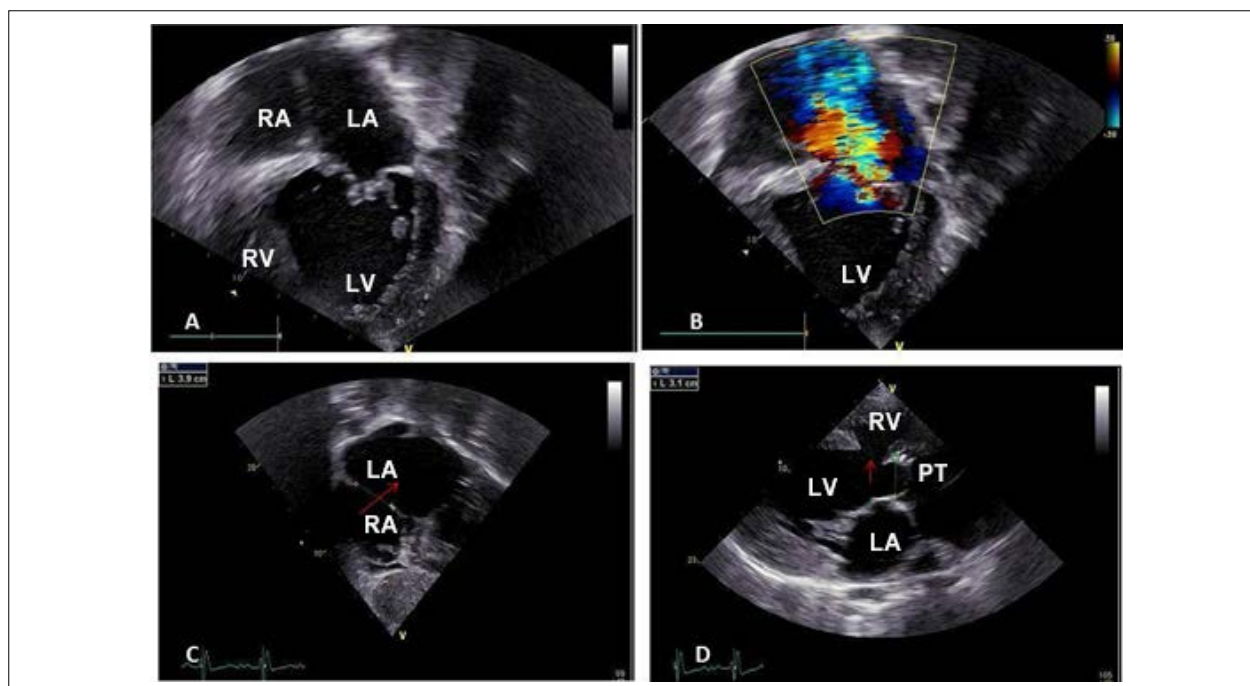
Echocardiogram highlights the marked increase in left heart cavities with right atrioventricular valve atresia and very hypoplastic right ventricle in subcostal view in A; marked mitral regurgitation in B; the large interatrial septal defect (arrow) in subcostal view in C; and the long-axis view image in D showing the interventricular septal defect (arrow) and the pulmonary valve-LV connection, characterizing type IIB tricuspid atresia. RA: right atrium; LA: left atrium; PT: pulmonary trunk; RV: right ventricle; LV: left ventricle.
